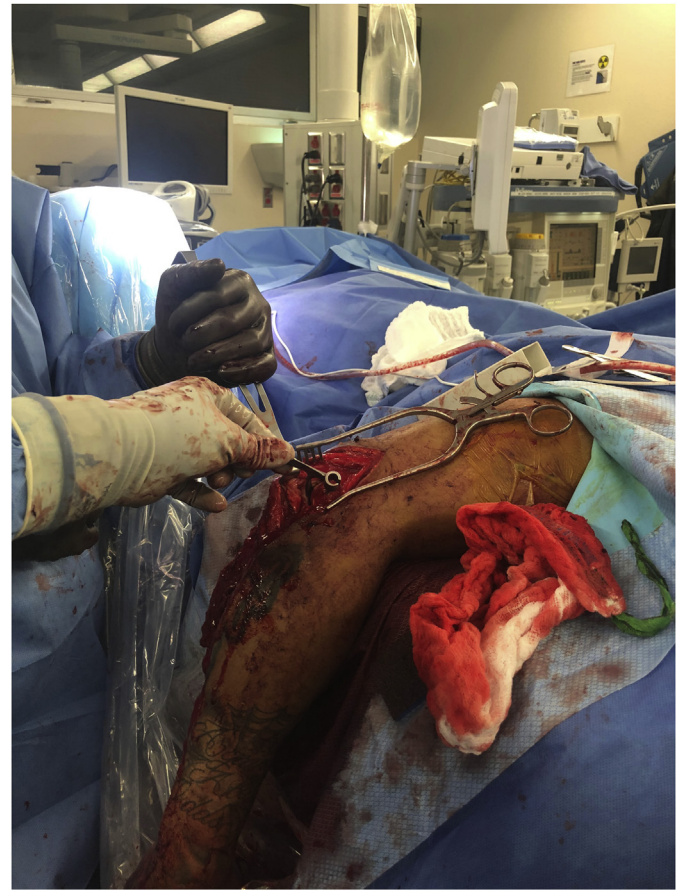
Surgeon positioning the patient for the lateral radiograph. Note: Use of C-Arm and radiolucent bed optimizes the efficiency of getting intraoperative radiographs.
